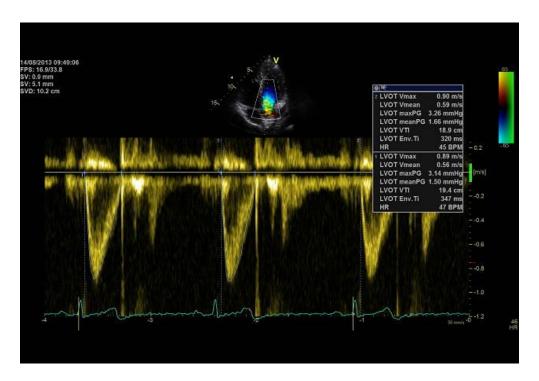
Spectral Doppler recording demonstrating measurement of left ventricular outflow tract velocity-time integral (used in the calculation of stroke volume).
